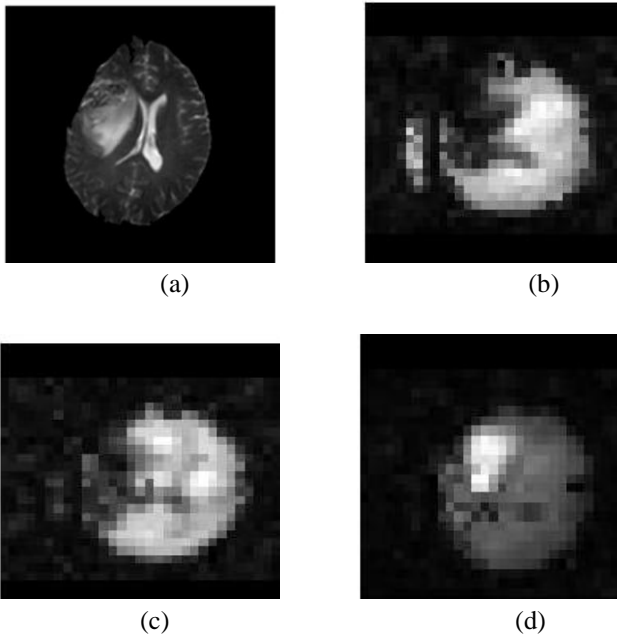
A 30-year-old man with right frontal brain tumor. a) T2-weighted image. b) NAA metabolite map, c) Cr metabolite map, d) Cho metabolite map. The decrease of NAA, Cr and increase of Cho represents abnormal region.
